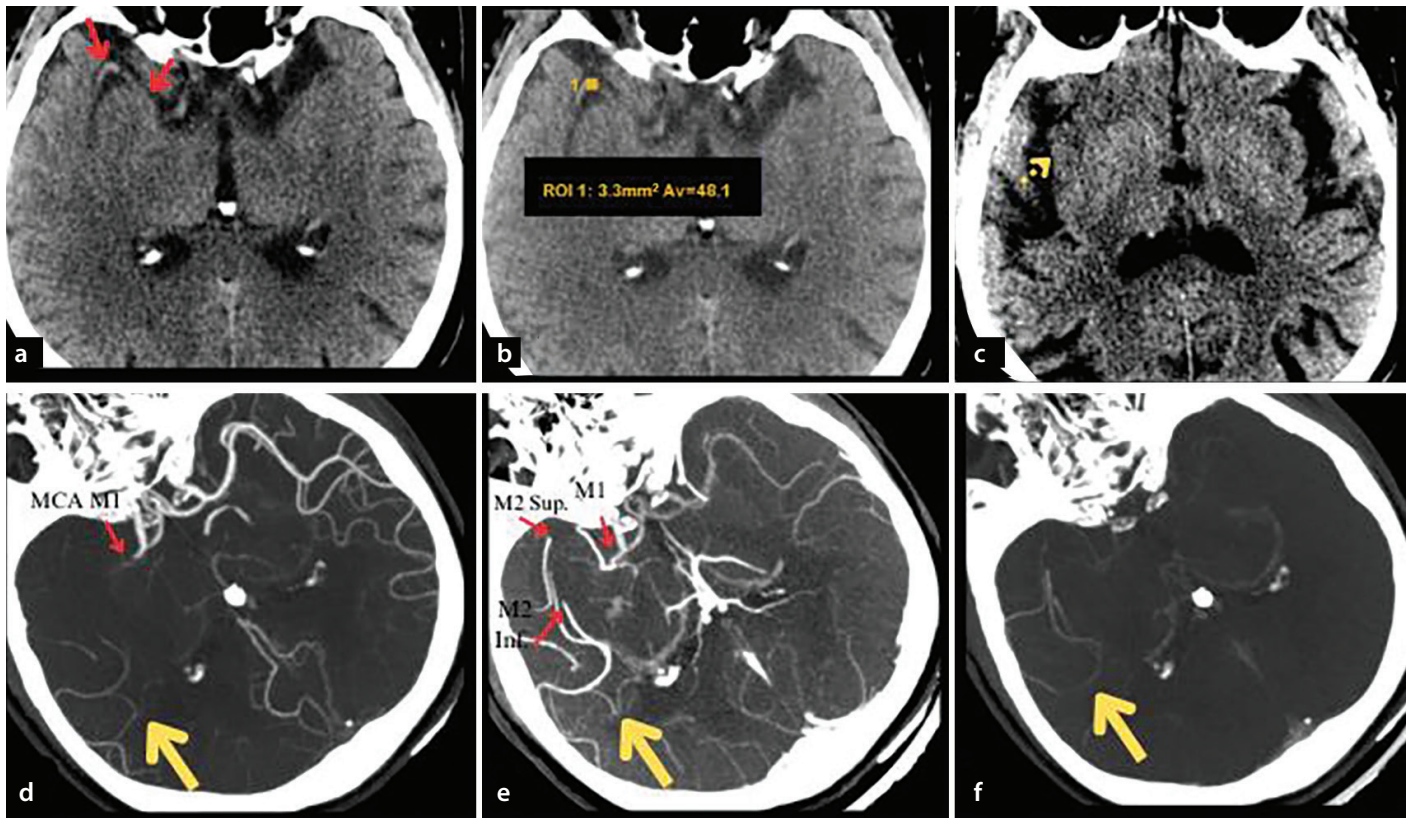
Non-contrast CT and mCTA images (a-f) of a 70-year-old man with acute ischemic stroke. The time from symptom onset to mCTA was 47 minutes. (a) The proximal M2 segment of the MCA was slightly hyperdense, but the M1 segment was isodense on NCCT (red arrows). (b) Thrombus density was calculated as 48 Hounsfield units (yellow square). (c) Axial NCCT image (width: 40; level: 30) at the level of the basal ganglia shows mild hypodensity (dotted yellow arrow) consistent with early ischemic changes in the right insula (ASPECTS: 9). (d) Arterial and (e) early venous phase MIP mCTA images show the thrombus extending from the proximal M1 segment to the superior (M2 sup) and inferior (M2 inf) divisions of the M2 segment in the MCA. The actual thrombus length, best delineated on early venous phase mCTA images (red arrows), measured 31 mm from the M1 segment to the M2 inferior division (not shown). The clot burden score was calculated as $10 - 2 - 2 - 1 - 1 = 4$ points. (d) Arterial, (e) early venous, and (f) late venous phase MIP mCTA images show a one-phase delay in collateral filling (yellow arrows) in the peripheral vessels (grade 4 collateral circulation). Although successful recanalization was achieved with mechanical thrombectomy, the patient passed away after hospital discharge (90-day modified Rankin scale score = 6). NCCT, non-contrast computed tomography; mCTA, multiphase computed tomographic angiography; ASPECTS, Alberta Stroke Program Early CT Score; MIP, maximum intensity projection; mCTA, multiphase computed tomographic angiography; CT, computed tomography.
